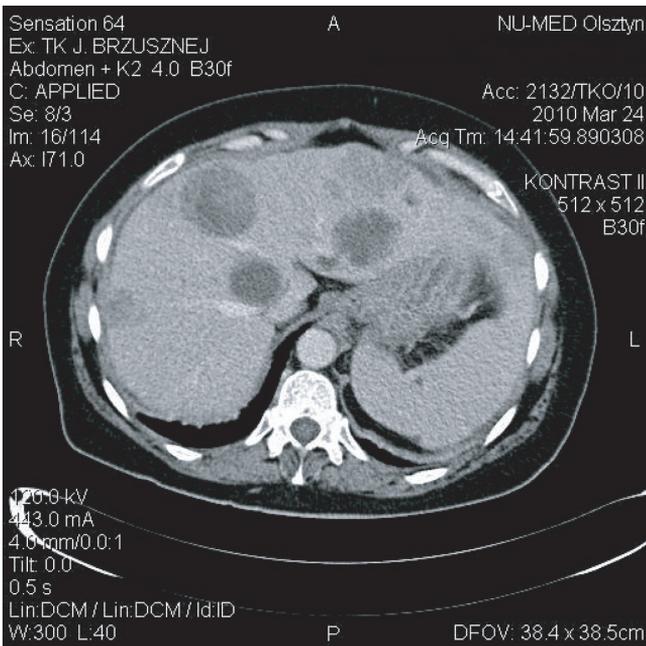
Abdominal CT scan (liver). Multiple hypodense areas
